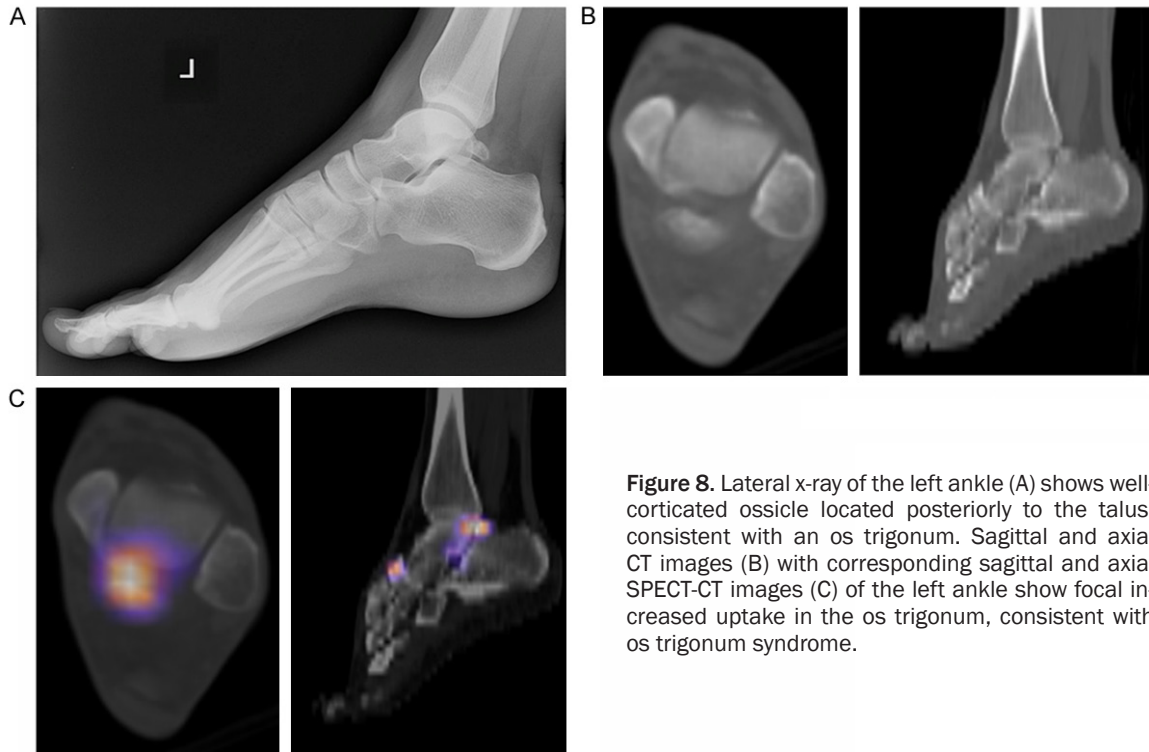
Lateral x-ray of the left ankle (A) shows well-corticated ossicle located posteriorly to the talus, consistent with an os trigonum. Sagittal and axial CT images (B) with corresponding sagittal and axial SPECT-CT images (C) of the left ankle show focal increased uptake in the os trigonum, consistent with os trigonum syndrome.
